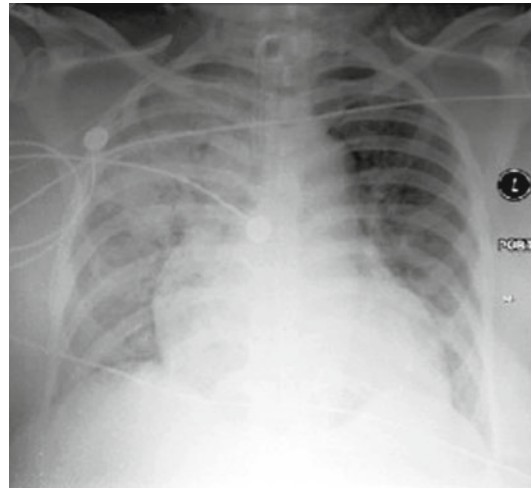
Portable chest X-ray demonstrating right lung consolidation with increased opacity in the right lower lobe more than the right upper lobe. Left lung is clear
